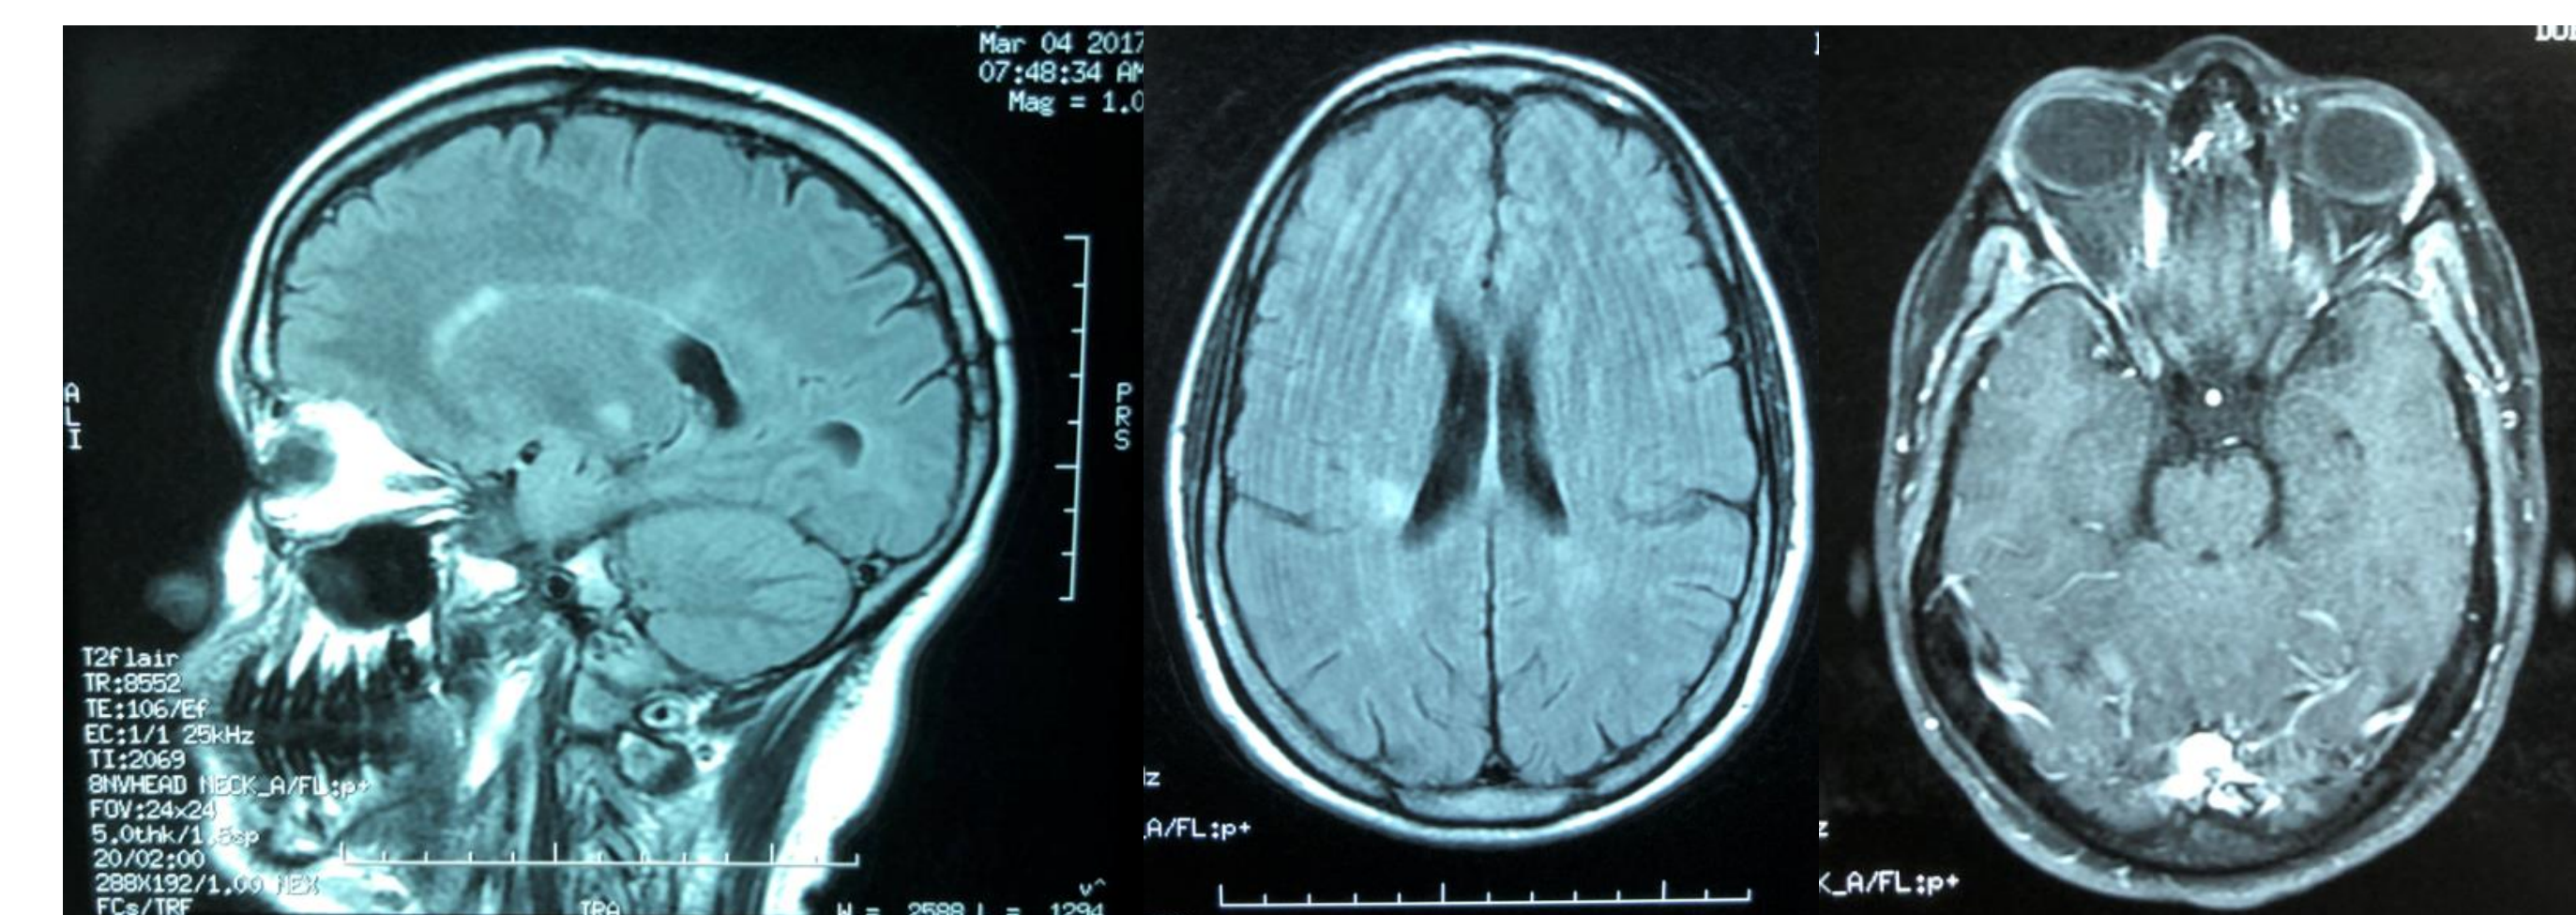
Left image shows a sagittal view of patient's MS lesions. Middle shows the new lesion that was demonstrated in MRI performed on 11/2016. Right image shows resolution of enhancing lesion from 2015 brain MRI. No lesions were enhancing in this MRI.
